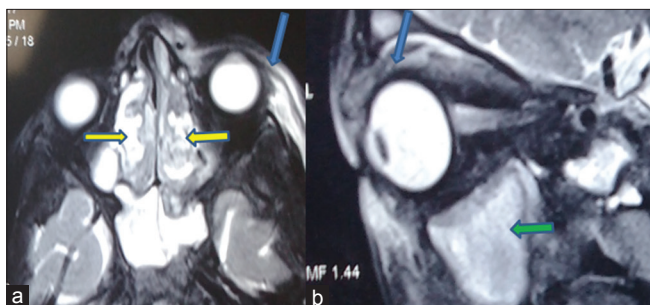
MRI orbit and paranasal sinuses axial (a) and coronal scan (b) showing ethmoid (yellow arrows) and maxillary sinusitis (green arrows) and left early superior orbital cellulitis involving superior rectus muscle (blue arrows)
